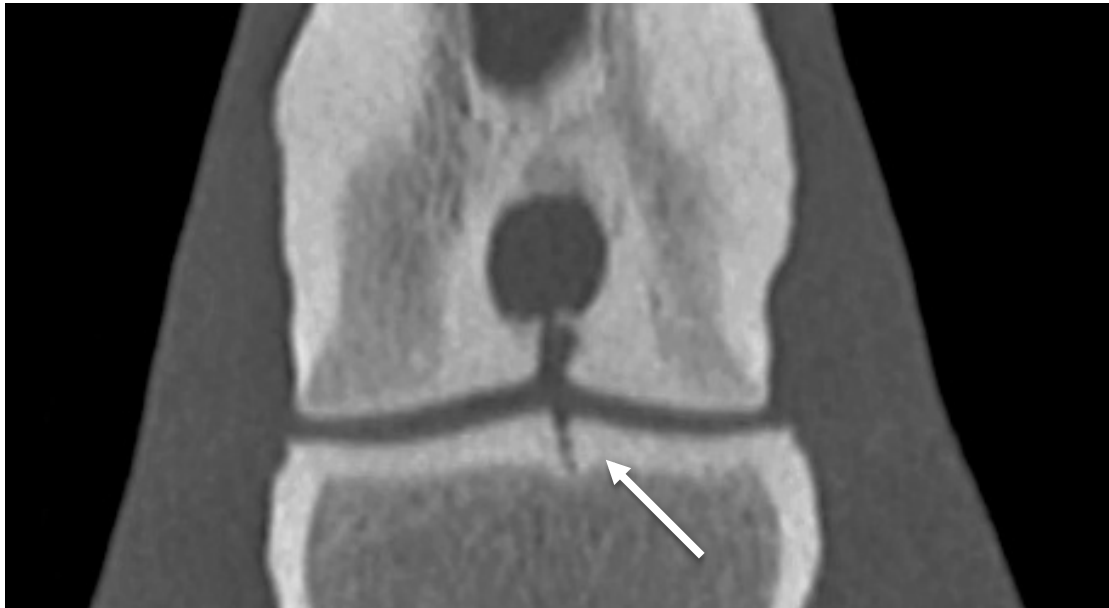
Dorsal CT view showing the same SCL with a clear connection to the near cartilage and a kissing split-like lesion (arrow) in the opposite subchondral bone of the proximal aspect of P2. There is a marked hyperintense rim around the oval SCL.
